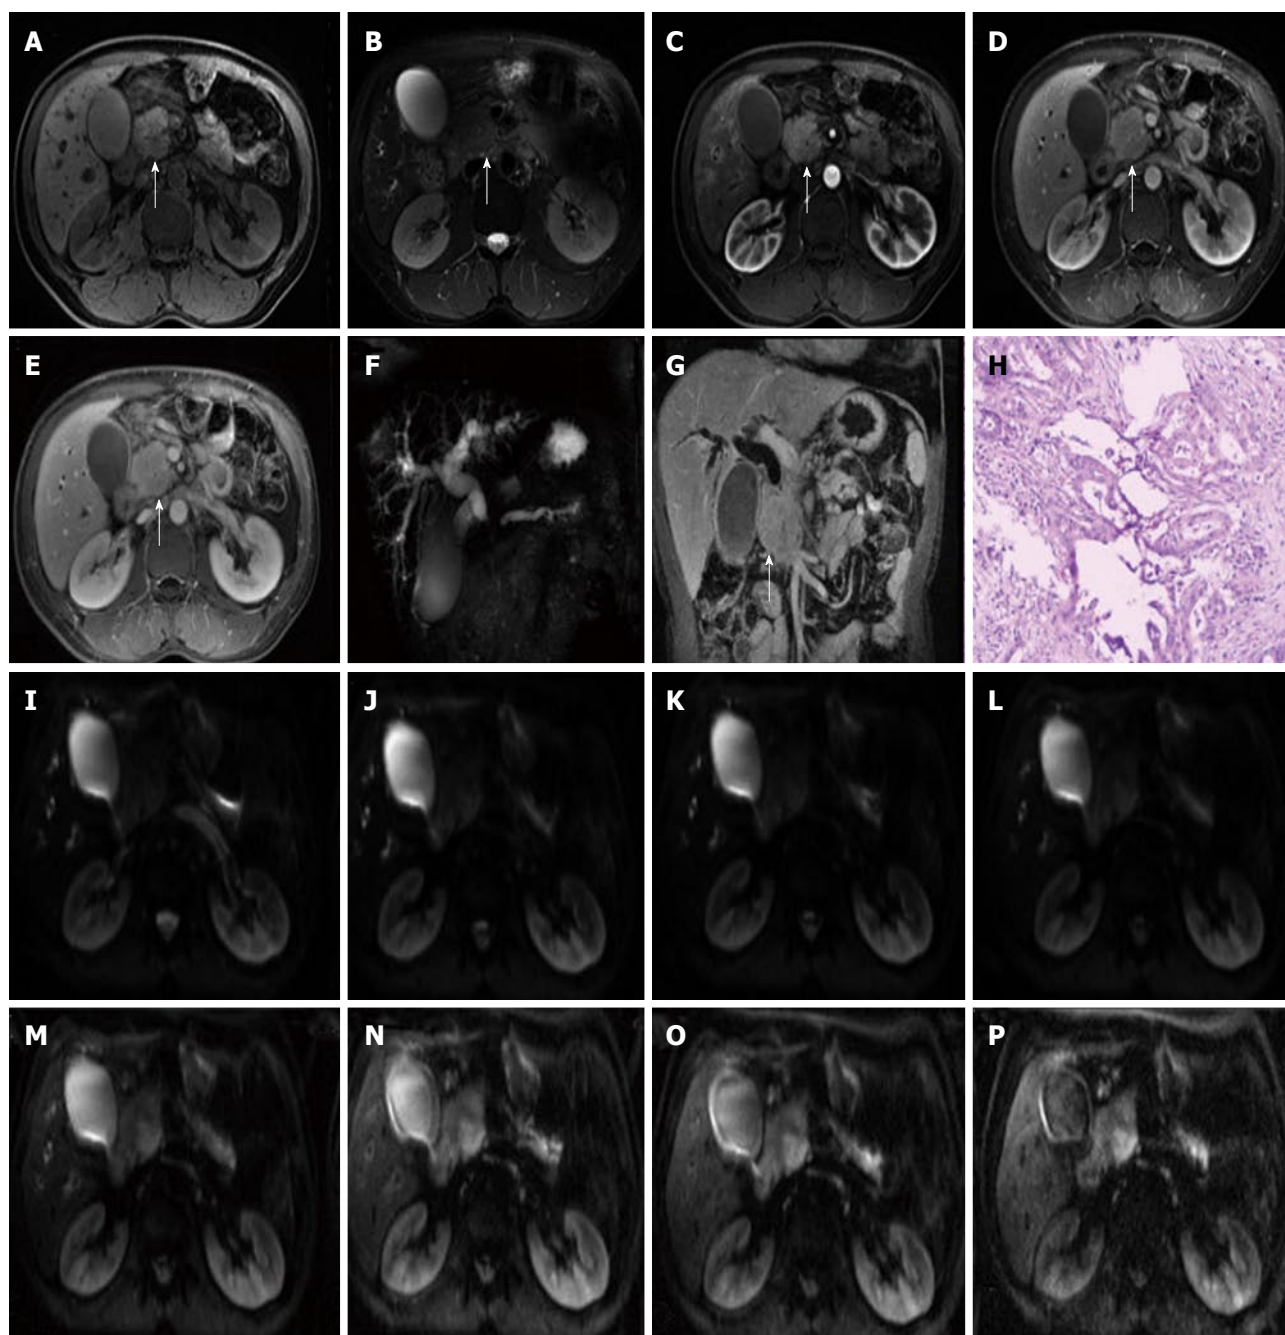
Images in a 47-year-old man with pancreatic moderately differentiated adenocarcinoma in the head of the pancreas (white arrows). A: Axial T1-weighted fat-suppressed gradient-echo MR image; B: Axial T2-weighted fat-suppressed fast spin-echo MR image; C-E and G: Axial and coronal slab three-dimensional liver acquisition with volume acceleration dynamic contrast-enhanced; F: MRCP shows the biliary obstruction; H: The pathology of the lesion is shown as pancreatic moderately differentiated adenocarcinoma; I-P: Multi-b DWI imaging ($b = 0, 50, 100, 300, 500, 800, 1000$ and 1500). MR: Magnetic resonance; DWI: Diffusion weighted imaging; MRCP: Magnetic resonance cholangiopancreatography.
